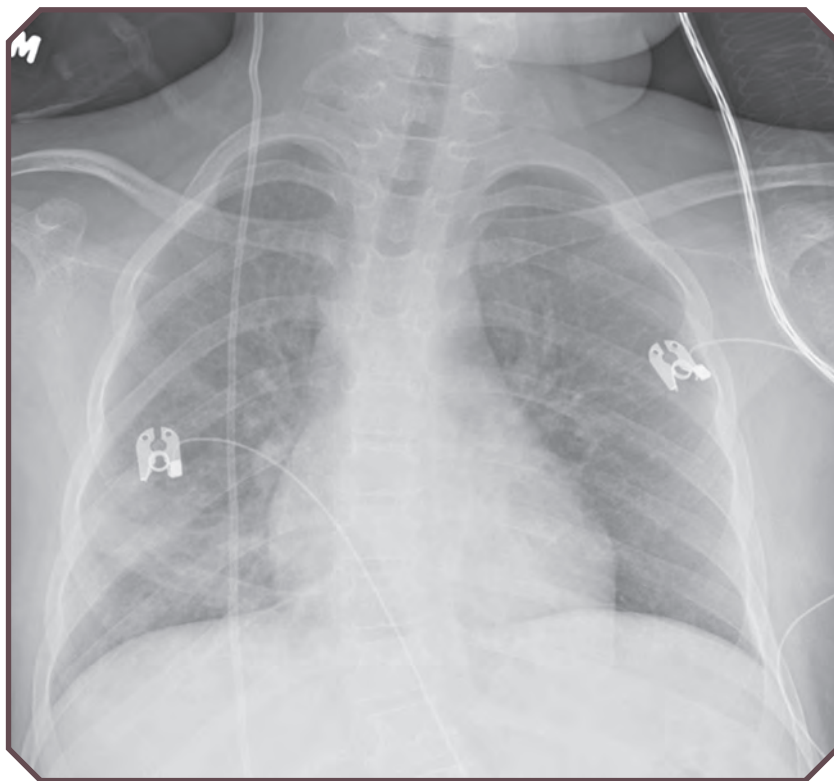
Adenovirus pneumonia in an 8-year-old hospitalized child. Frontal chest radiograph demonstrates diffuse, bilateral, fine perihilar opacities with no focal air space disease or effusions. Also note ventriculoperitoneal shunt tubing vertically oriented over the right hemithorax.
